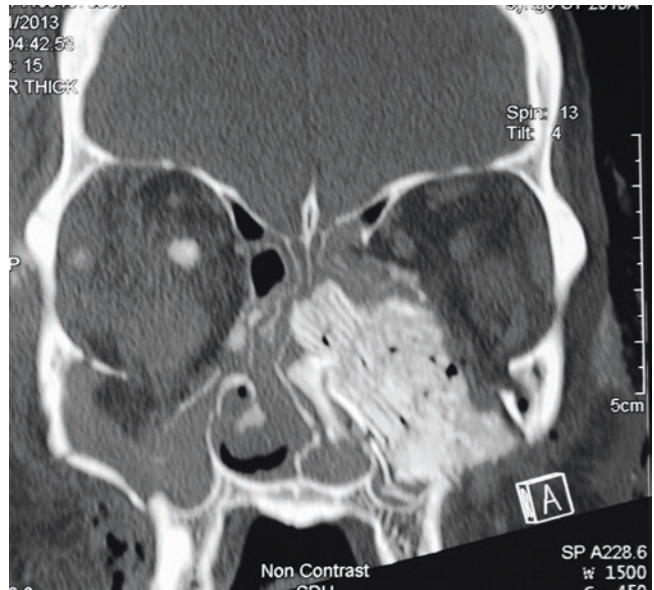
CT scan, coronal cut showing bony and soft tissue NLD disruption following a blast injury
